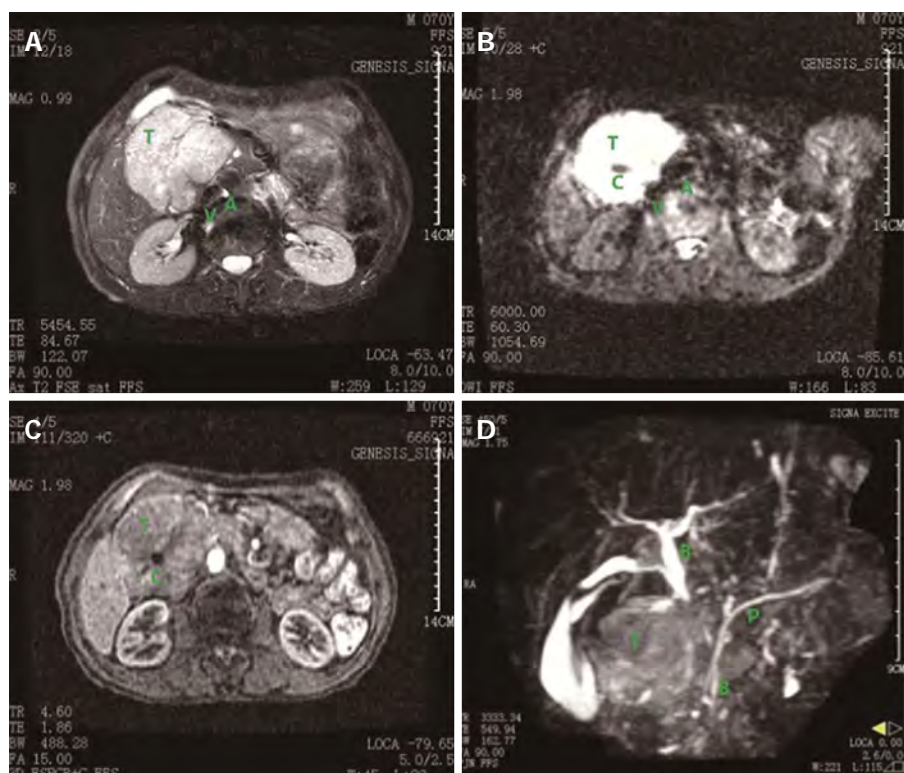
Respective magnetic resonance imaging images. A-C: For case 4; D: For case 22. T: Tumor; C: Necrotic core; A: Abdominal aorta; V: Inferior vena cava; B: Common bile duct; P: Main pancreatic duct.
